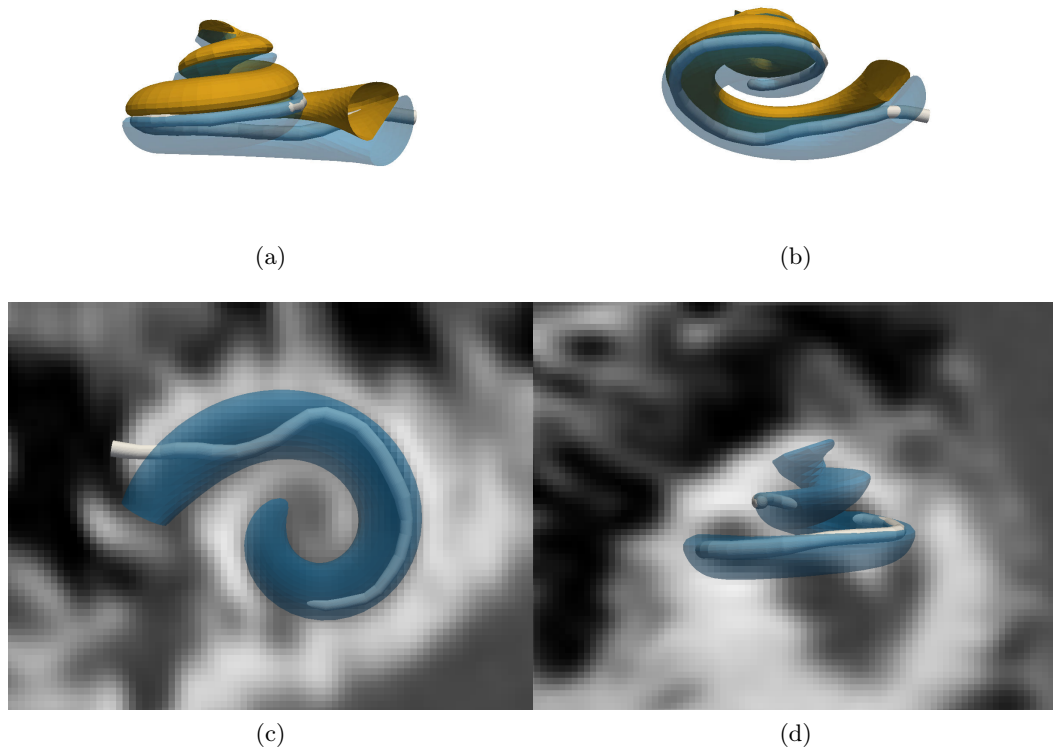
Post-implantation electrode position obtained by rigid registration between pre- and postoperative CT image with cochlear and electrode model fitting.
